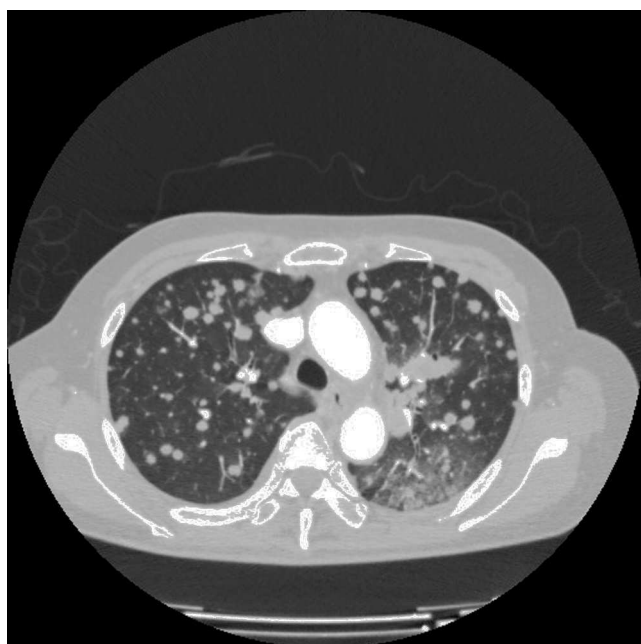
Chest computed tomography. Image showing multiple bilateral pulmonary nodules after progression on erlotinib.
